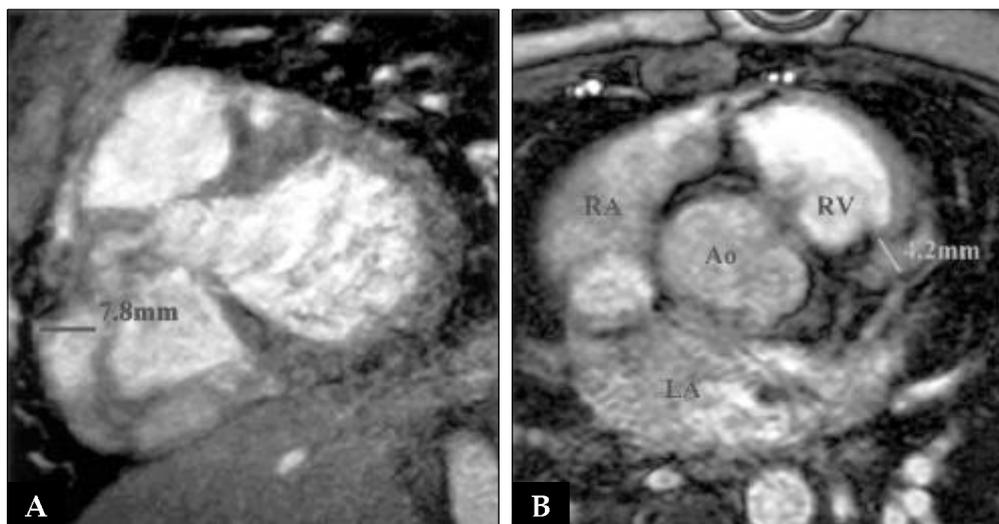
Heart MRI on day 104, showed a multifocal coronary aneurysm on the entire right coronary artery (maximum: 7.8 mm)(A) proximal to the mid left anterior descending artery (maximum: 4.2 mm)(B).
